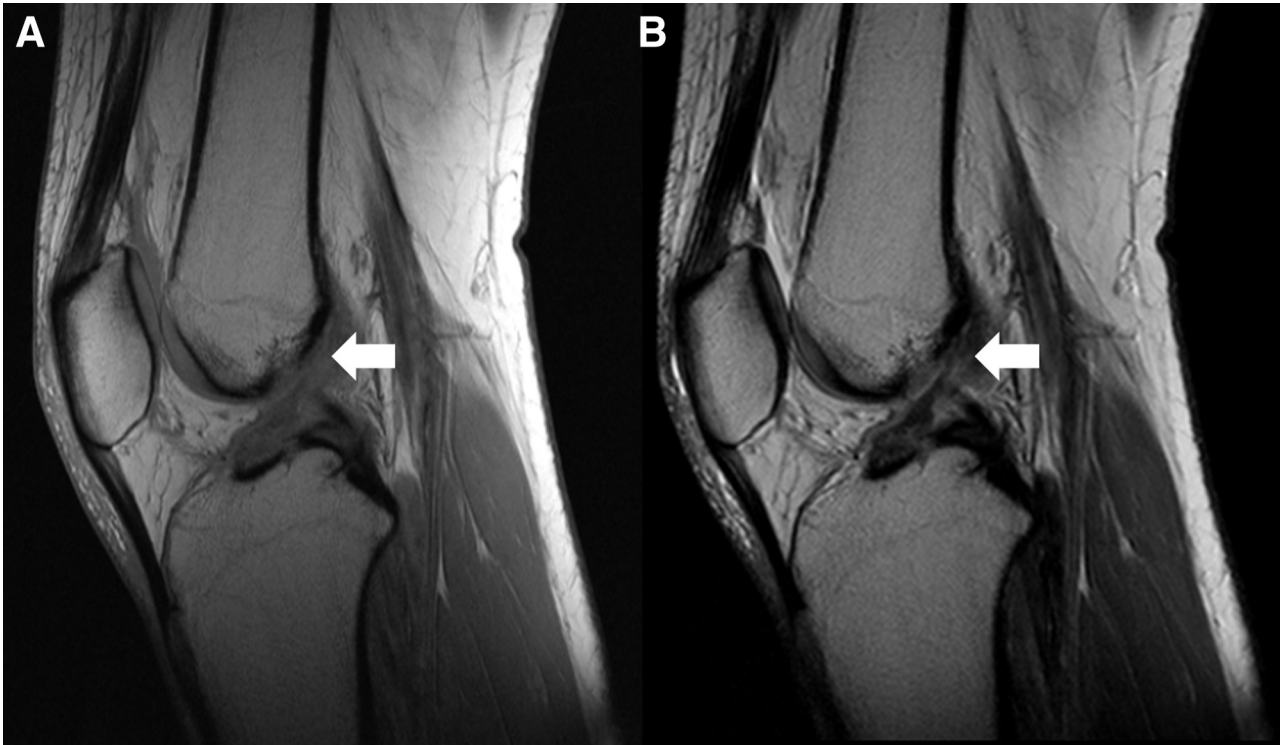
Two sagittal magnetic resonance images (T1 [A] and T2 [B]) of right knee showing partial anterior cruciate ligament tear (arrows).
